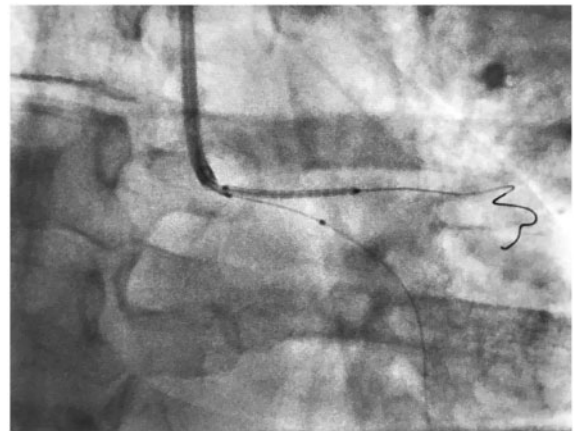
A 4.0 × 23 mm Xience Sierra™ stent was placed with simultaneous live intravascular ultrasound-guidance achieved by passing the intravascular ultrasound catheter over the circumflex artery guidewire.
